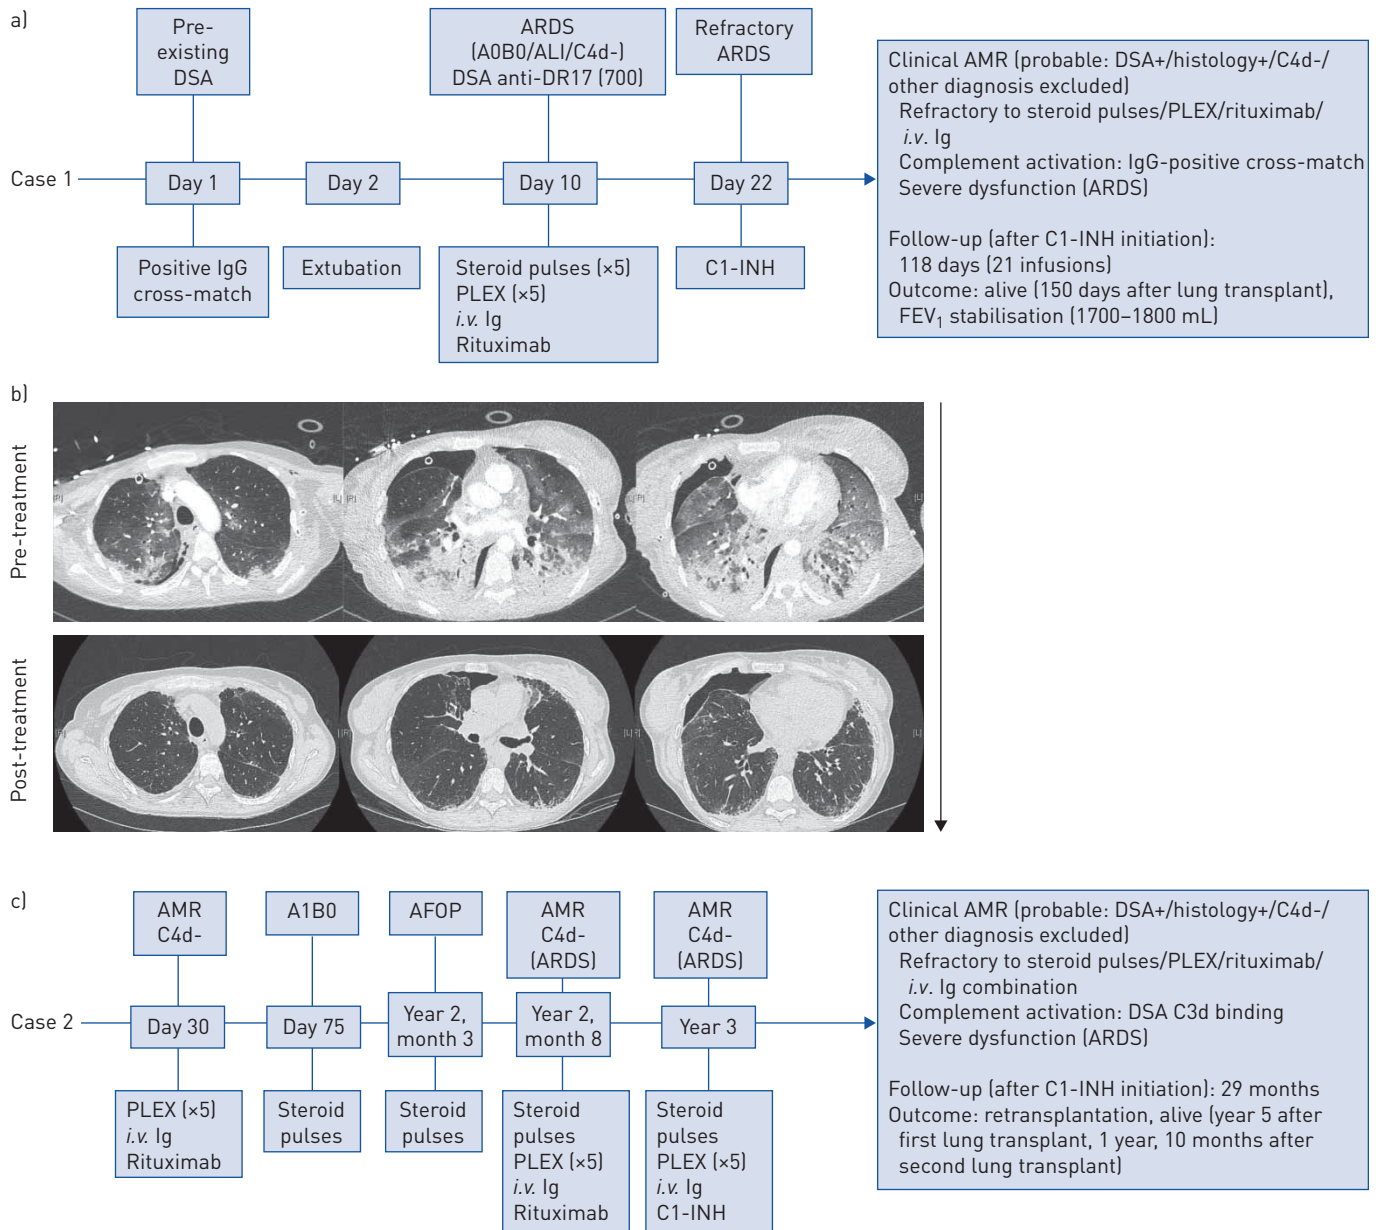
a) Timeline for case 1, 22-year-old woman who underwent bilateral lung transplantation for end-stage cystic fibrosis. b) Case 1: lung computed tomography (CT) scan before C1 esterase inhibitor (C1-INH) initiation on day 10 and CT scan at month 4 after first lung transplantation. c) Timeline for case 2, 38-year-old woman who underwent bilateral lung transplantation for cystic fibrosis. DSA: donor-specific antibody; ARDS: acute respiratory distress syndrome; ALI: acute lung injury; PLEX: plasma exchange; AMR: antibody-mediated rejection; FEV₁: forced expiratory volume in 1 s; AFOP: acute fibrinous and organising pneumonia.
